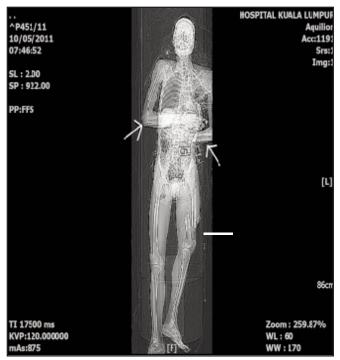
Topogram in coronal view showing standard body positioning during post mortem CT scan. Note the position of upper limbs (white arrow) which caused streak artefacts to the liver and spleen from hands and forearms bones.
